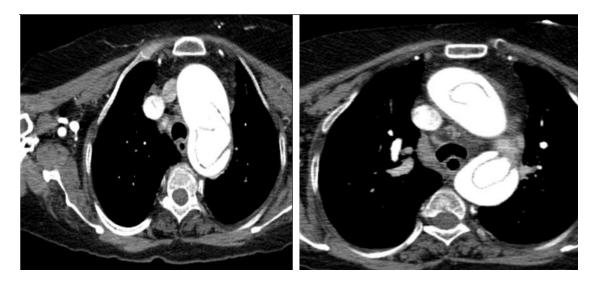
Computerized Tomography(CT) image of the patient
